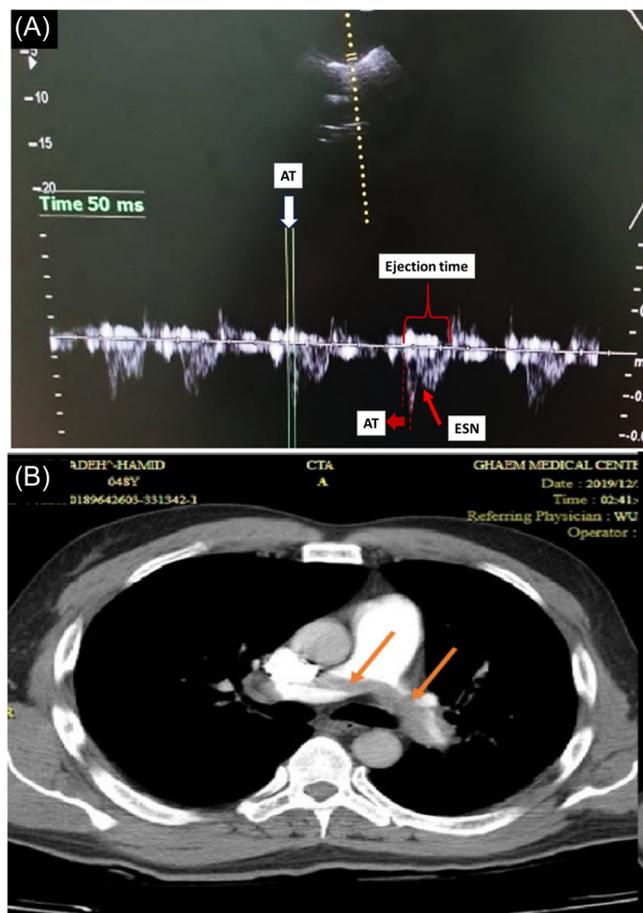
(A) Acceleration time (AT), ejection time (ET), Early systolic notching (ESN) in right ventricular outflow tract Doppler patterns; (B) Arrows show clot in left and right pulmonary artery.
